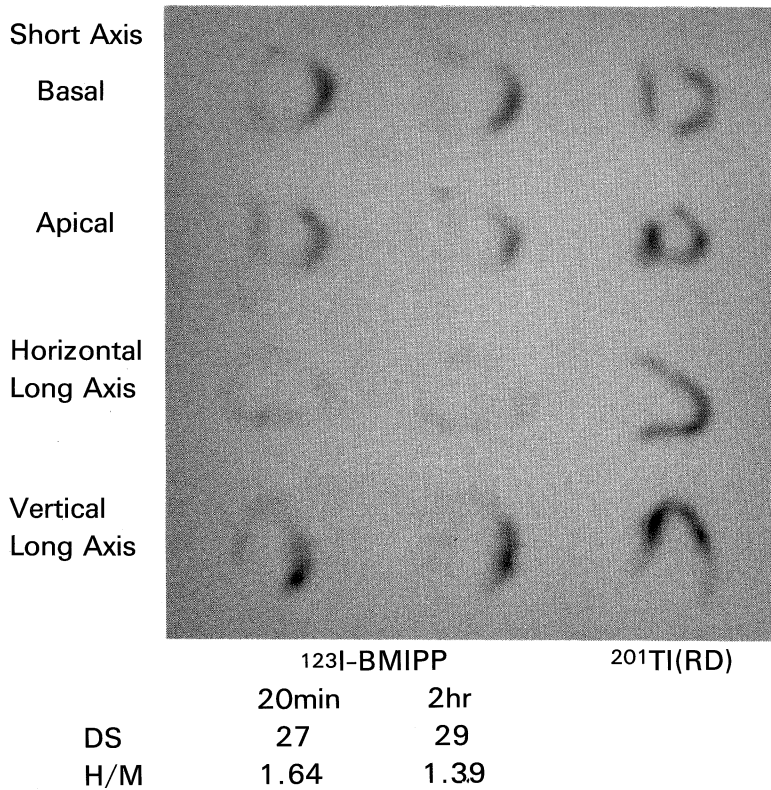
Case 2 (ASH type) SPECTs using ¹²³I-BMIPP and ²⁰¹Tl
